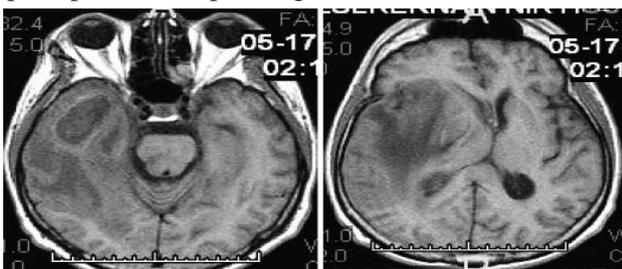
Figure III & IV: Heterogeneous hypointense lesions in the right inferior temporal area in T1-weighted MR imaging.
